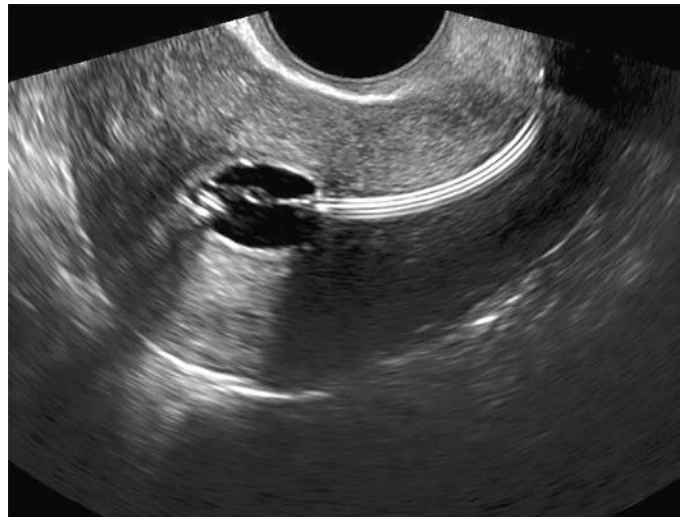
A 28-year-old woman with menorrhagia. Longitudinal transvaginal sonography of the uterus obtained during a normal saline infusion sonohysterographic examination shows insertion of the catheter and inflation of the balloon just past the internal cervical os. The balloon is inflated with saline to avoid shadowing and obscuration of the posterior uterine wall by gas.
